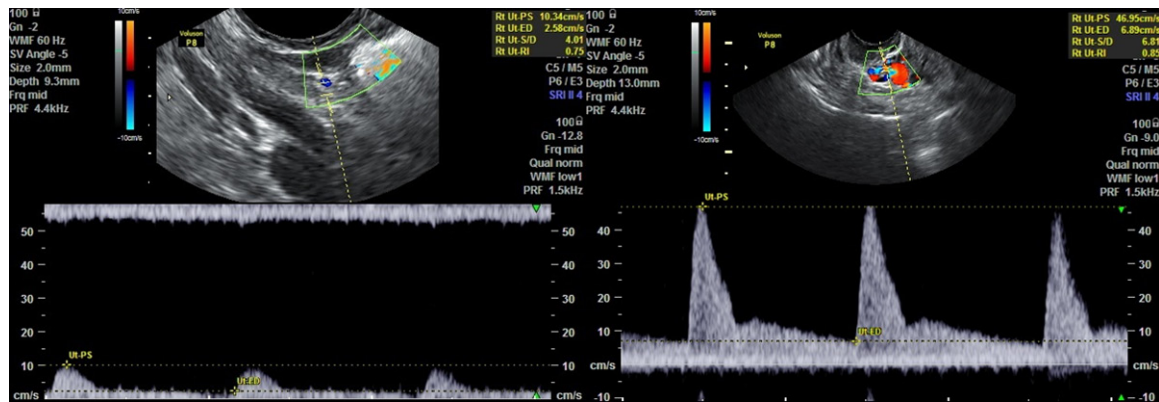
Uterine arterial blood flow velocity waveforms were obtained by means of color flow imaging to identify the ascending branch of the uterine artery on the left and right sides of the uterine isthmus. For each examination, the mean value of three consecutive waveforms was obtained (Color doppler flow imaging for patient group in left side and for control group in right side).
